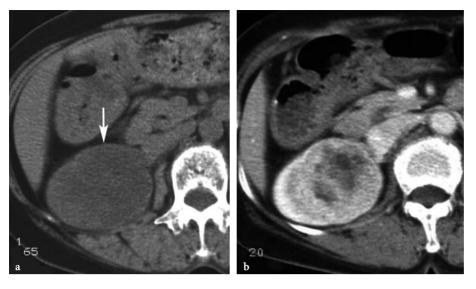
Collecting duct carcinoma in a 64year-old woman. a Axial unenhanced CT scan shows a hypodense mass (*arrow*) with preservation of the right renal contour. b Axial contrast-enhanced CT scan shows moderate, heterogeneous enhancement of the tumor.
